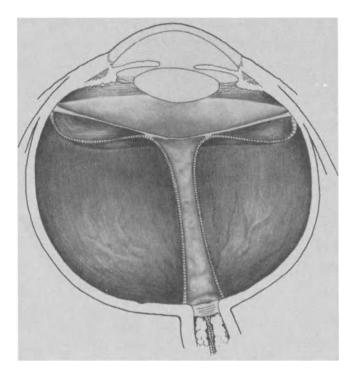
Grade 8 vitreoretinal traction indicates a highly and totally detached retina caused by excessive traction from a highly detached posterior hyaloid and cyclitic-like membrane causing the retina to be positioned in the retrolenticular space. This produces a characteristic ultrasonographic echo resembling a triangle – the so-called triangular syndrome.
